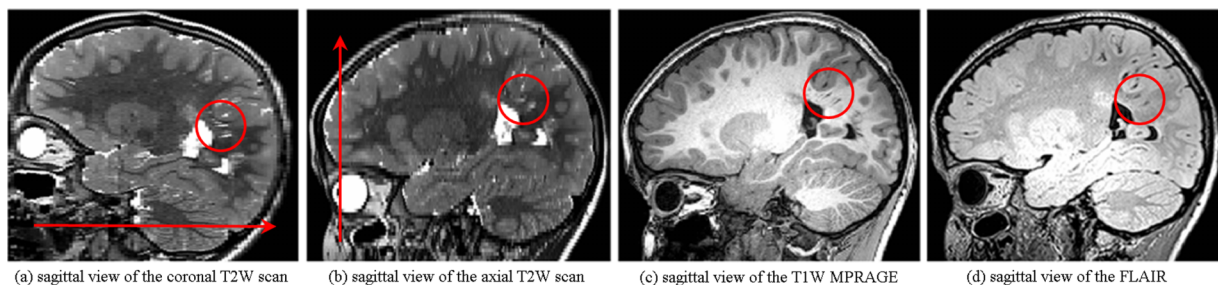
This figure shows the out-of-plane sagittal views of (a) the axial and (b) the coronal FSE scans of a TSC patient, (c) the corresponding sagittal view of a T1W MPRAGE scan, and (d) the corresponding sagittal view of a FLAIR scan of the same patient; the arrows show the slice select direction on the FSE scans; circles highlight some of the thin structures with axis that were almost exactly parallel to the slice select direction in the coronal FSE scan so could be appropriately visualized on the coronal FSE scan despite the 2 mm slice thickness. Image (b), on the other hand, shows that these thin structures may easily be obscured by partial volume effect when they are not parallel to the slice select direction. Although the details of the anatomy have been visualized on the high-resolution MPRAGE and FLAIR scans, many of these structures, such as the abnormal radial bands of white matter, are best visualized by T2W FSE scan.
